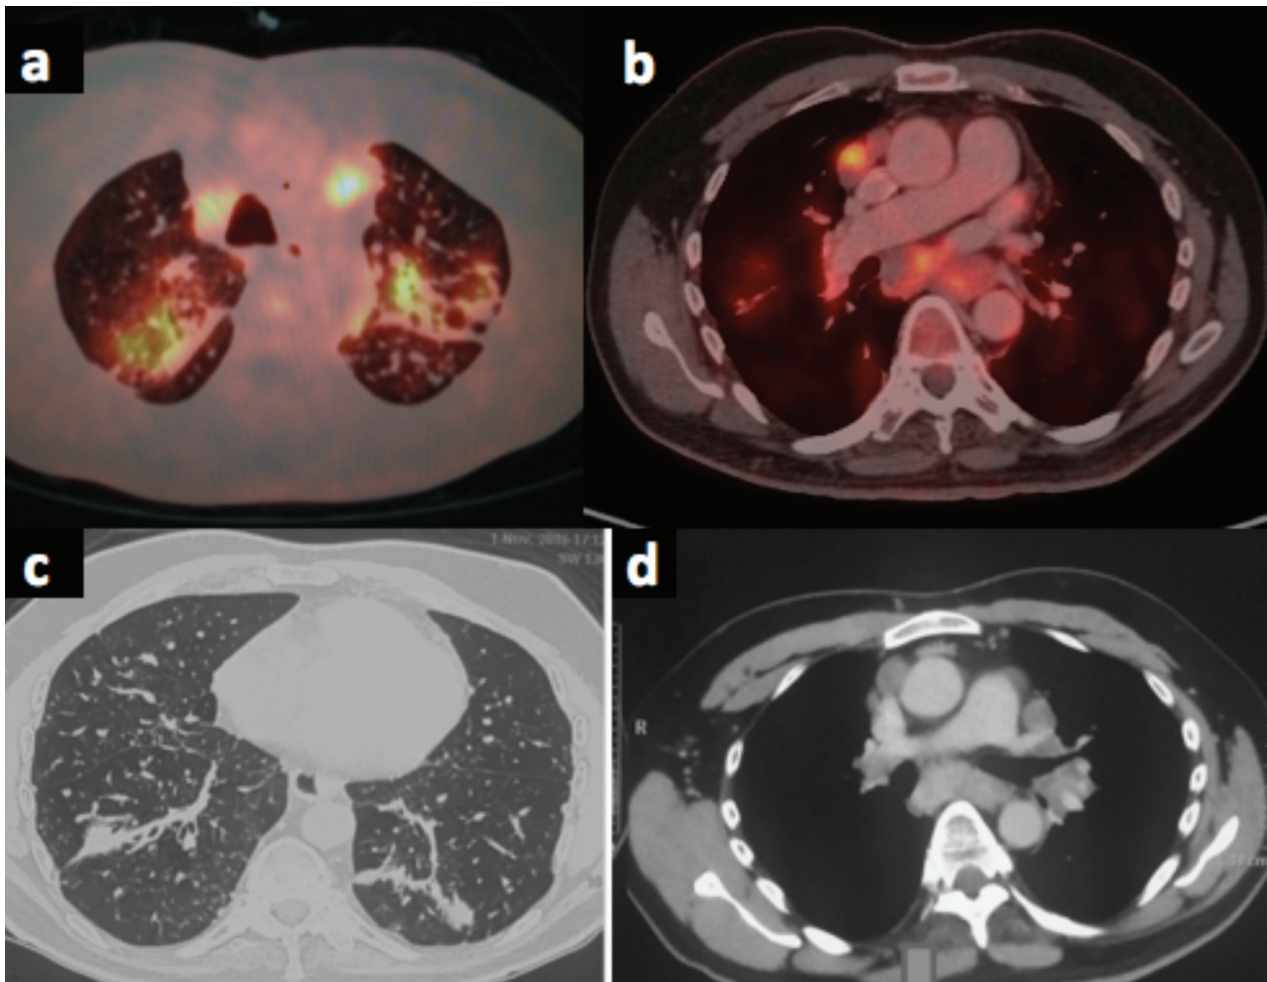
a) PET showing FDG avid multiple bilateral pulmonary nodules in bronchovascular distribution. b) PET showing multiple FDG avid mediastinal lymph nodes. c) & d) High resolution CT showing improvement in lung lesions as compared to Figure 1c and regression in the size of lymph nodes as compared to Figure 1d
